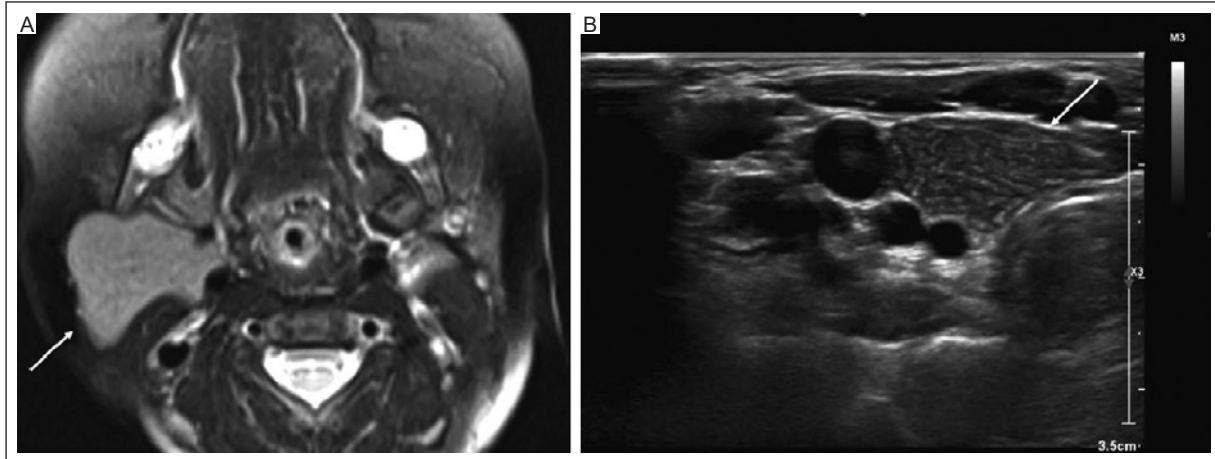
Ectopic/cervical thymus. A: axial T2-weighted fat-suppressed MRI, and B: ultrasound of the neck show a well-circumscribed lobulated T2 hyperintense mass in the right neck, anterior to the sternocleidomastoid and carotid sheath with homogeneously distributed speckled hyperechoic foci on ultrasound, consisted with ectopic thymus (arrows).
